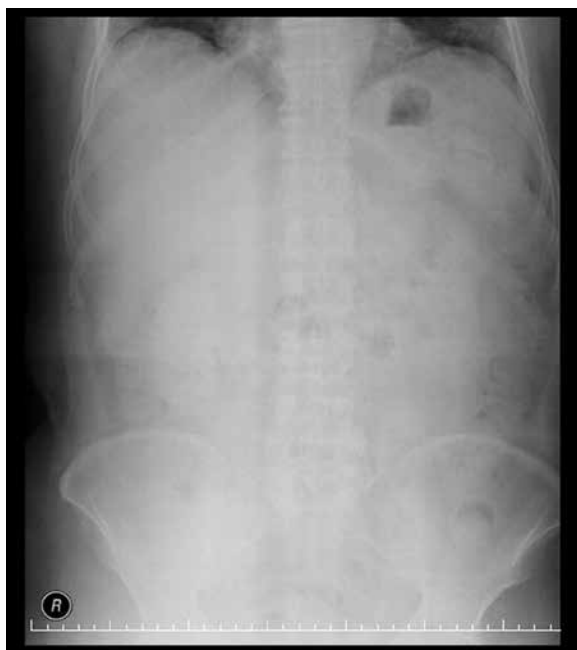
Abdominal plain radiography; there are no specific findings.
